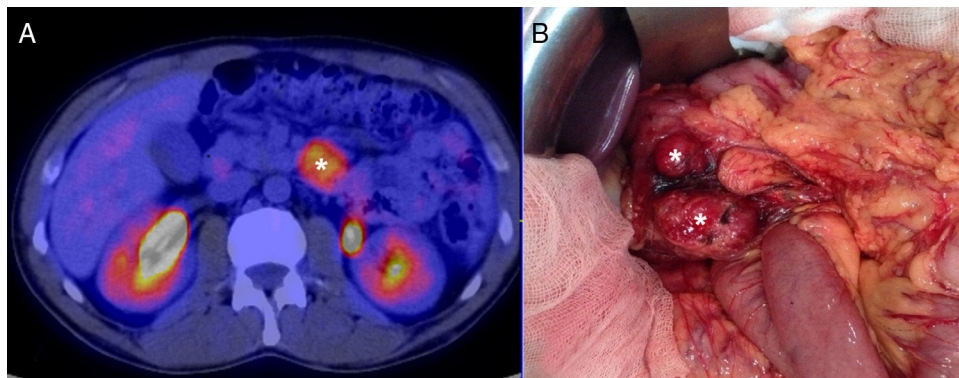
(A) PET/CT image showing the duodenal lesion, marked with (*). (B) Intra-operative image showing two tumours in the third and fourth parts of the duodenum, marked with (*).
